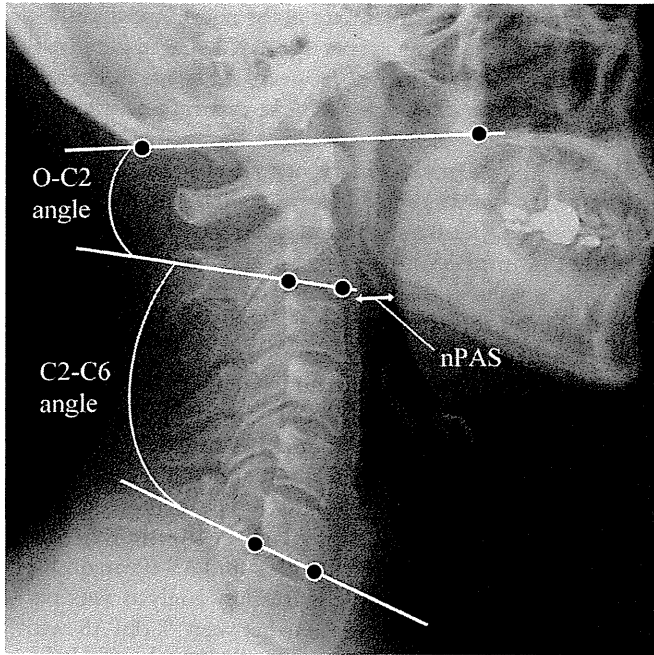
Representation of radiographic measurements. The O-C2 angle represents the angle between the McGregor's line and the inferior endplate of C2. The C2-C6 angle represents the angle between the inferior endplates of C2 and C6. nPAS represents the narrowest anterior-posterior distance from the posterior pharyngeal wall to the back of the tongue between the levels of the uvula tip and the epiglottis tip.
